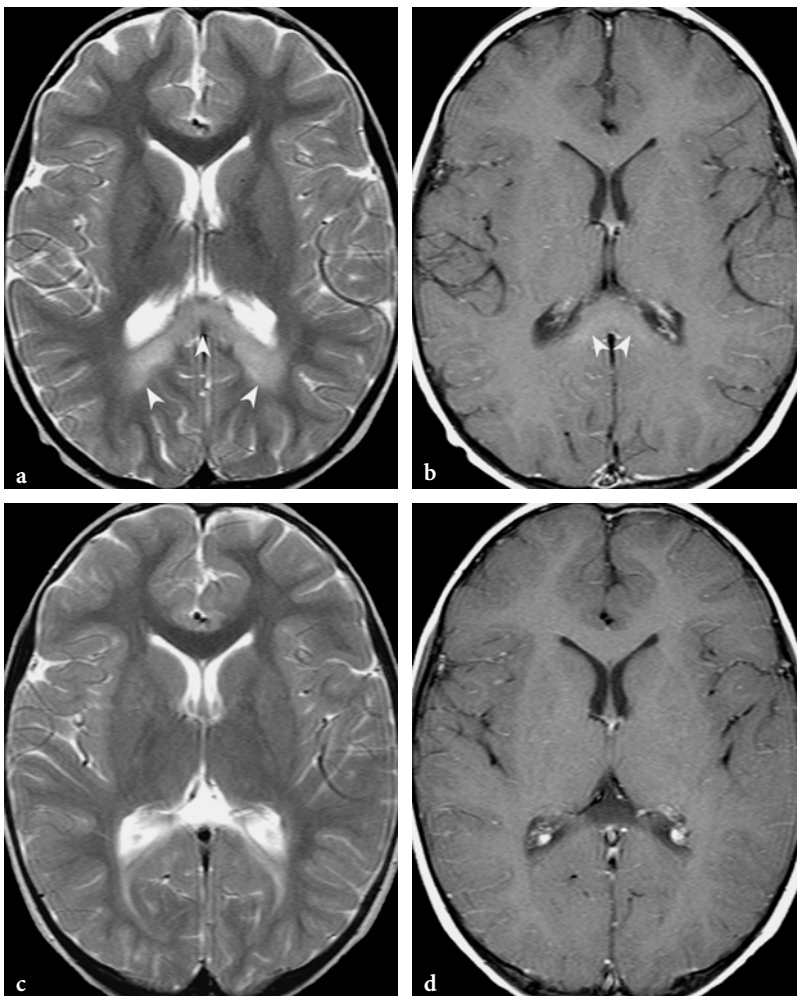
Monitoring response to therapy (bone marrow transplantation) in a male patient with X-linked adrenoleukodystrophy by conventional MR imaging. a Initial MR examination at the age of 4 years shows ill-defined hyperintensities on T2-weighted fast spin-echo image within the splenium of the corpus callosum and the deep occipital white matter (arrowheads). b Gadolinium-enhanced T1-weighted spin-echo image shows faint signal enhancement within the splenium (arrowheads). c One-year follow-up examination shows shrinkage of lesion area on T2-weighted fast spin-echo image. d At the same time, contrast-enhanced T1-weighted spin-echo image fails to show signal enhancement
